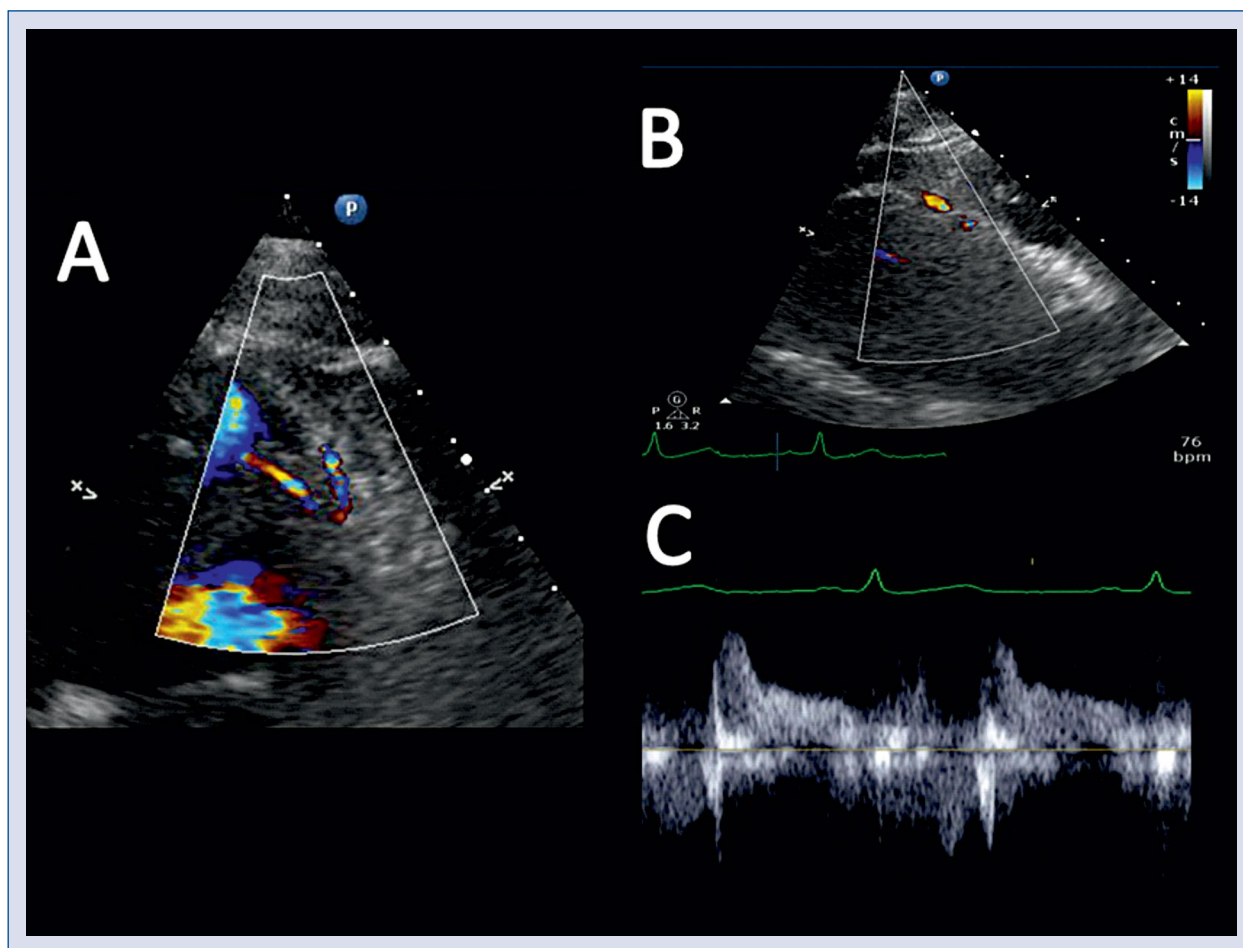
A. Modified parasternal short axis view. Color Doppler flow mapping in mid-diastole showing the bifurcation of left anterior descending artery (LAD) (to the right) with a large septal branch (to the left); B. Modified parasternal long axis view showing an antegrade (red) diastolic color Doppler flow in the anterior interventricular sulcus corresponding to the distal portion of the LAD; C. Pulsed wave Doppler with the sample volume positioned on the color Doppler signal of the LAD showing a predominately diastolic antegrade flow.
